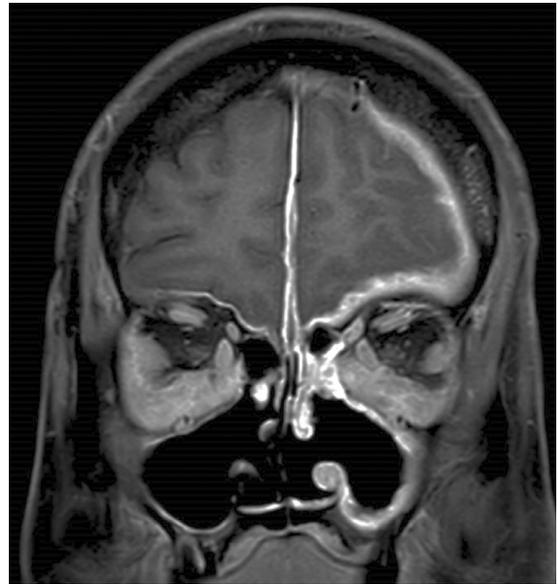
Coronal T1-weighted, fat-suppressed magnetic resonance imaging scan demonstrating enhancement of the pachymeninges and falx cerebri and inferior extraconal enhancing infiltrates in both orbits involving the periosteum.
